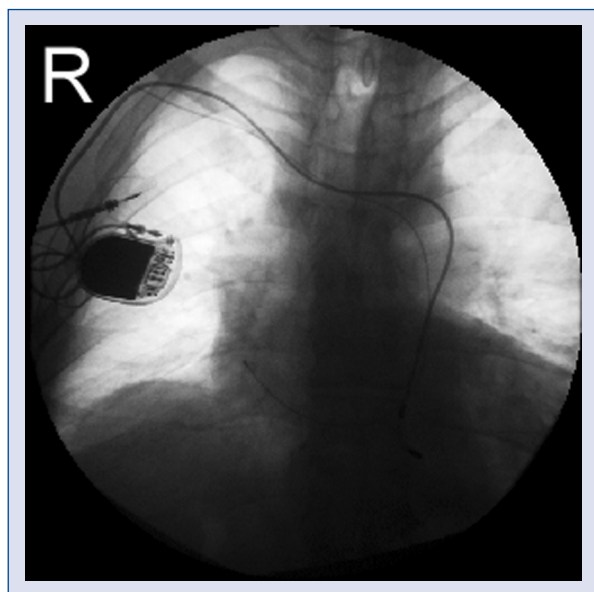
Postero-anterior chest radiograph of AAT BiA pacemaker. Leads are passing through persistent left superior vena cava and are positioned in right atrium free wall and coronary sinus (Case 1).
